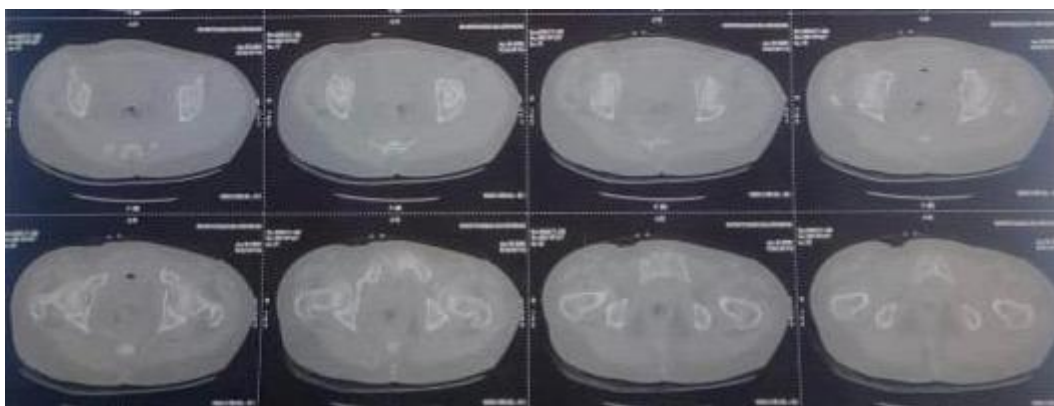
CT Pelvis Axial Cuts showing anterior column fracture
